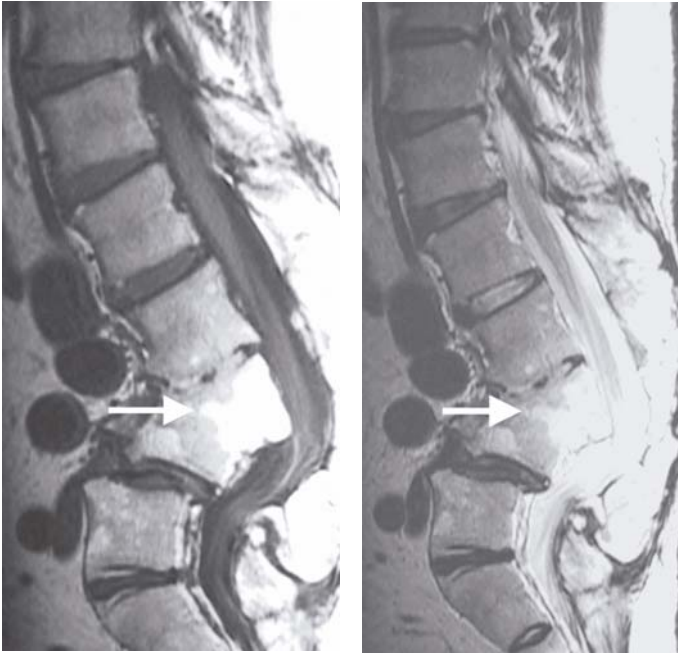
Follow-up MR imaging of an elderly man with previous TB spondylitis and now presenting with back pain. Sagittal (a) T1- and (b) T2-W images show bony ankylosis of the L3/4 vertebral bodies resulting in kyphosis. Fatty marrow infiltration is noted within the vertebral bodies (arrows). The adjacent spinal canal is deformed and narrowed.
